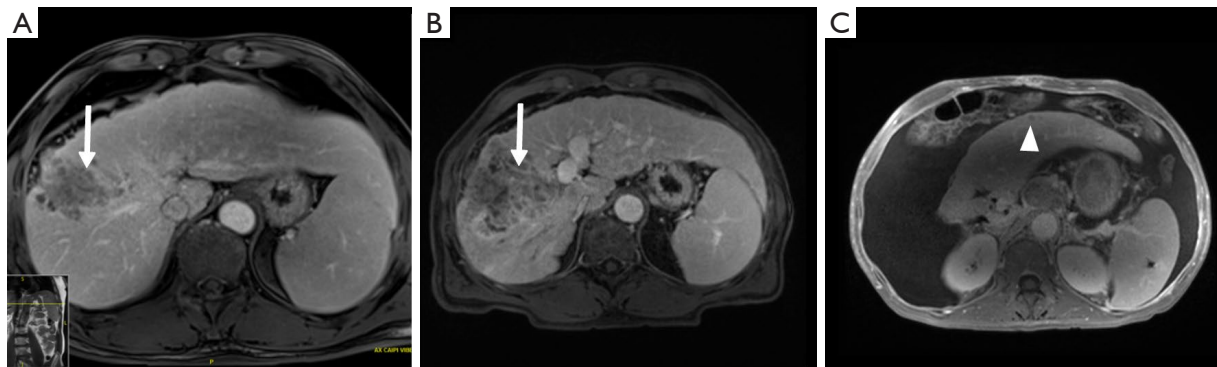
Post contrast MRI demonstrating a cirrhotic liver with hepatocellular carcinoma (arrow) in the right hepatic lobe (A). Post contrast MRI obtained one month after PVE demonstrates progression of tumor (arrow) and an FLR volume of 40% (B). Post contrast MRI obtained 3 months after right hepatectomy demonstrates liver failure with ascites and a subcentimeter tumor recurrence (arrow head) (C). PVE, portal vein embolization; FLR, future liver remnant.
